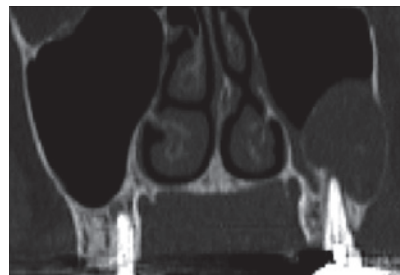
A radicular cyst is the most common extrinsic lesion to involve the maxillary sinus. This coronal CT demonstrates the thin sclerotic border that can help to differentiate at radicular cyst from a retention cyst arising in the maxillary sinus mucosa lining.
